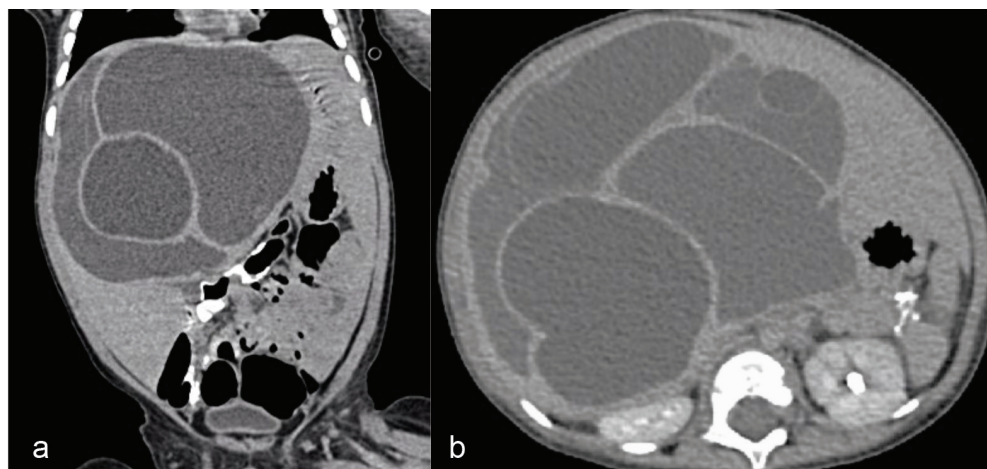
Selected CT scan images of the abdomen demonstrating a massive multi-lobulated cystic tumor at the right liver and the lesion-free segments II and III, a. coronal section, b. axial section.
